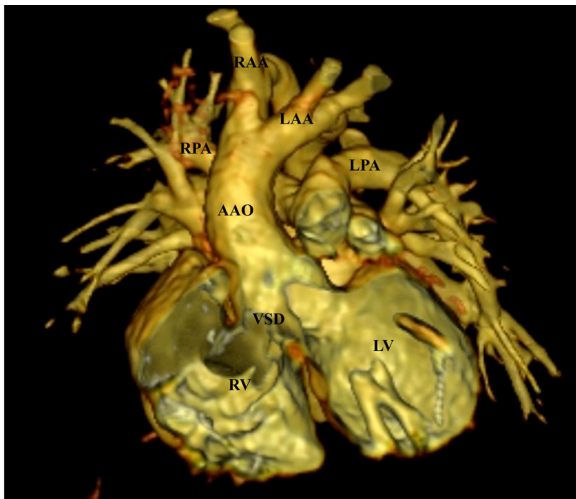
Computerized tomogram (CT) thorax revealed VSD, overriding of the aorta, and balanced DAA. AAO: ascending aorta; VSD: ventricular septal defect; LV: left ventricle; RV: right ventricle; LPA: Left pulmonary artery; RPA: Right pulmonary artery; RAA: Right aortic arch; LAA: Left aortic arch.
